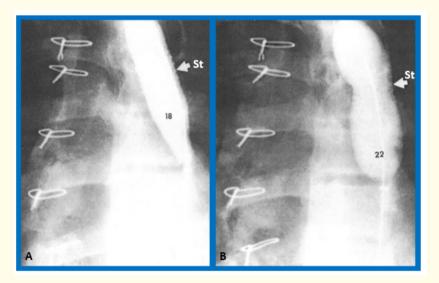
Selected cine-radiographic frame in 30° left anterior projection showing the position of the expanded stent (St) (arrow) following dilatation with an 18-mm-diameter balloon. B. Selected cine-radiographic frame in 30° left anterior projection showing position of the expanded stent (St) (arrow) following dilatation with a 22-mm-diameter balloon. Both images show complete expansion of the St (arrowheads). Numbers "18" and "22" indicate the size of balloon used to dilate the St. Sternal wires related to past surgery were seen, but not labelled.
